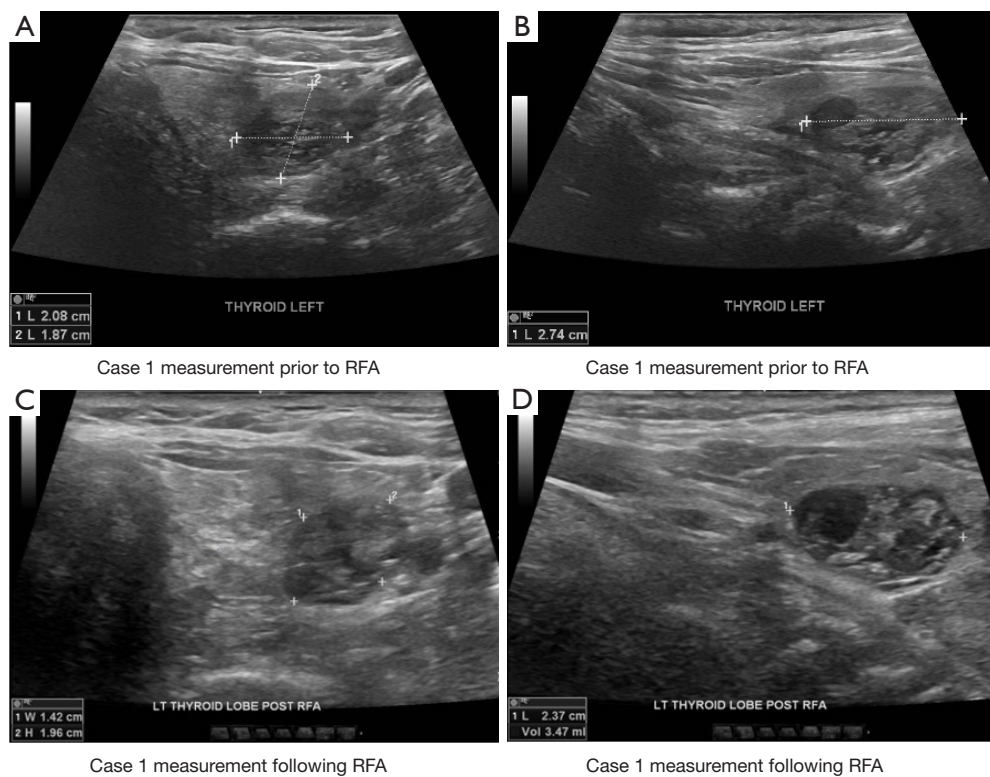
Sonographic images of case 1 prior to and one month following RFA. Volume decreased from 10.66 to 6.60 mL, indicating a 38.11% volume reduction rate. RFA, radiofrequency ablation.
